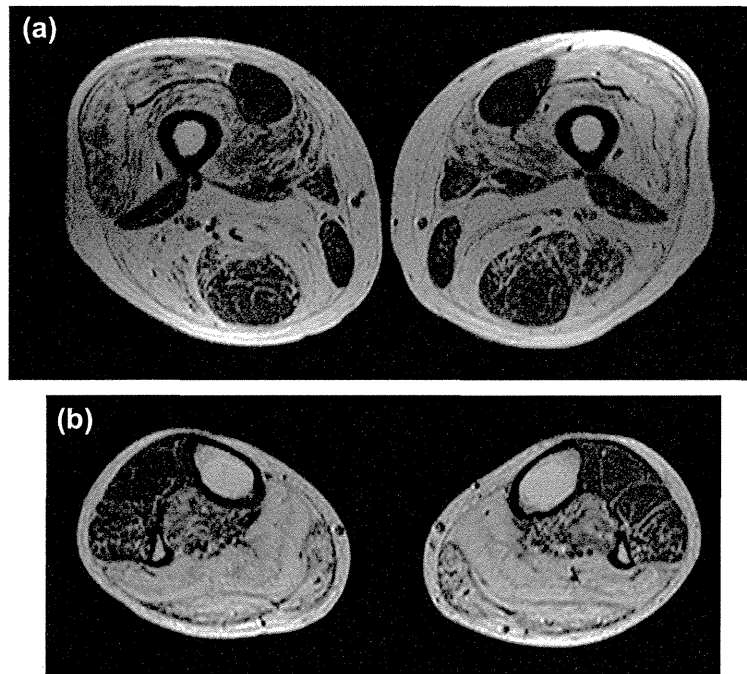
Muscle images of FA-2. Images of T2-weighted thigh (a) and lower leg (b) muscles using magnetic resonance imaging. Most of the thigh and calf muscles showed fatty replacement compared with the relatively well-preserved rectus femoris, sartorius, gracilis and anterior lower leg muscles.
